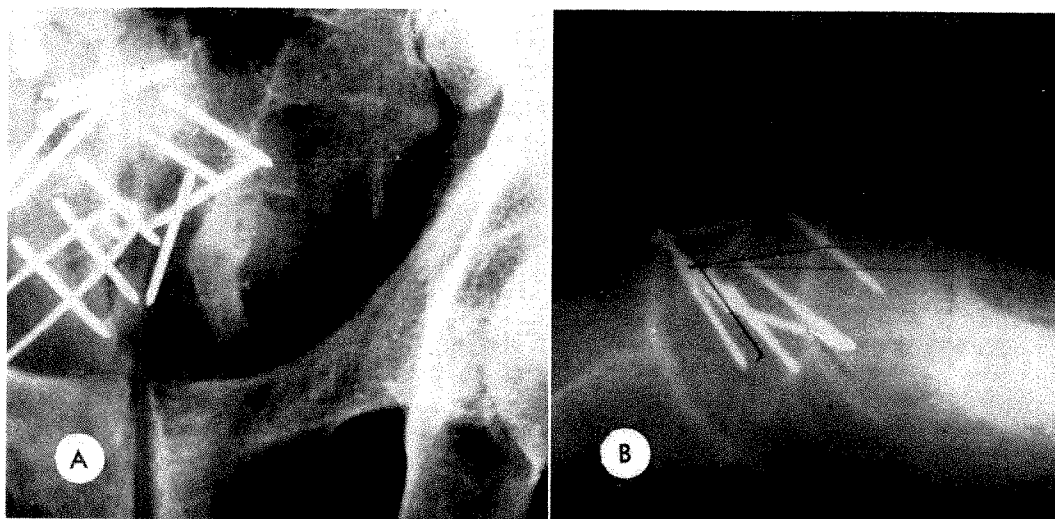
Residual carcinoma of the bladder following roentgen therapy. (A and B) An interstitial radium implantation was performed through a cystostomy.
